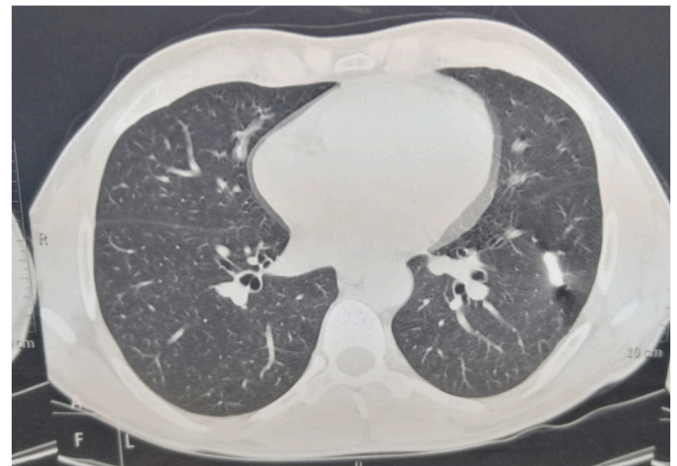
Native chest computed tomography scan shows bullet shaped metallic foreign body in the anterior segment of the left lower lobe.
